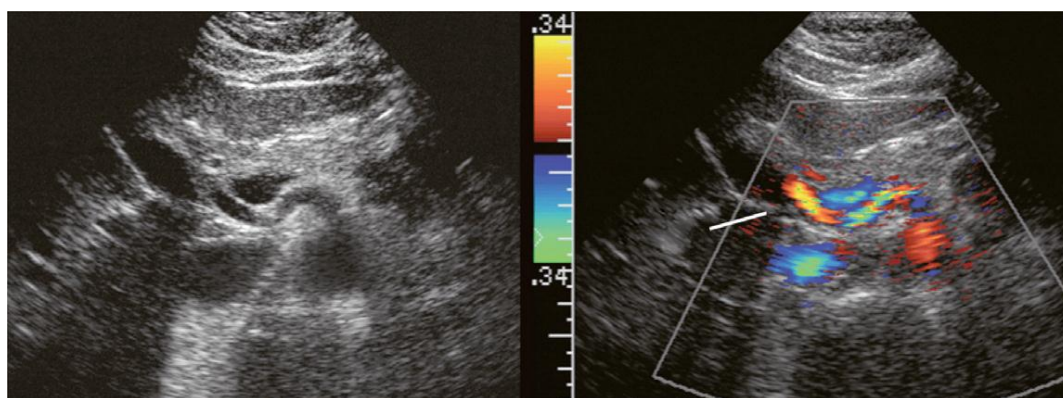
Transverse image of the mid-abdomen at the level of the superior mesenteric artery origin. A tubular structure is seen coursing from the superior mesenteric artery (SMA) to the right lobe of the liver, between portal vein (PV) and the inferior vena cava (IVC). The addition of colour Doppler identifies this tubular structure as a vessel. An arterial signal on spectral Doppler, identification of its SMA origin and a course towards the right lobe of the liver confirm this to be a replaced right hepatic artery.
